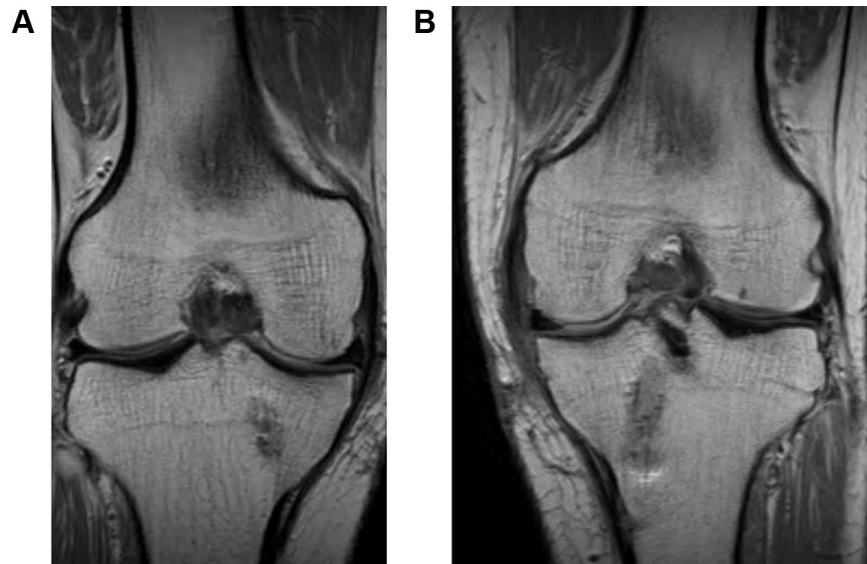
MRI of patient 2 obtained 13 months after medial MAT of both knees. (a, b) Coronal T1-weighted image of both knees showing sound peripheral healing of the joint capsule. The cartilage wear area on the medial femoral condyle side was well covered.
